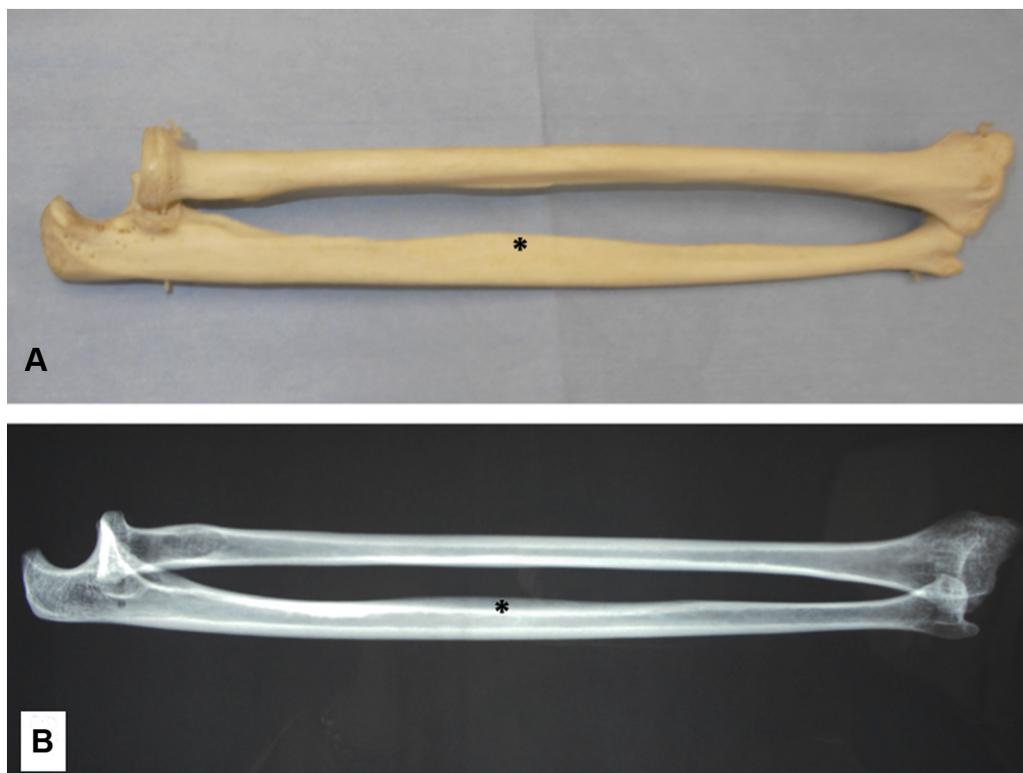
Photograph (A) and radiograph (B) of bleached human forearm bone. The protuberance of the anterior ulnar cortex is marked (*).
